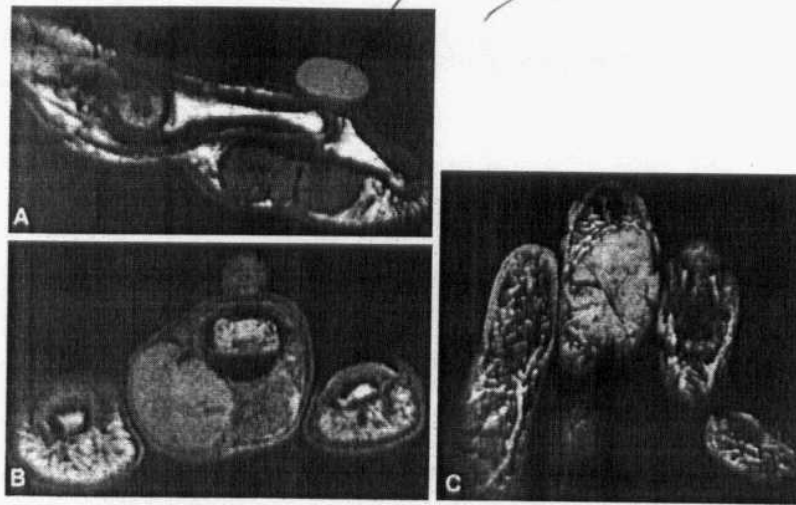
Giant cell tumor of the flexor tendon sheath is low to intermediate in signal intensity on T1-weighted sagittal (A) and axial (B) images. On volar T2*-weighted coronal images through the phalanges, however, it demonstrates intermediate intensity. On T2*-weighted sequences due to the effect of hemosiderin(Quoted from Stoller and Brody, 1997).
